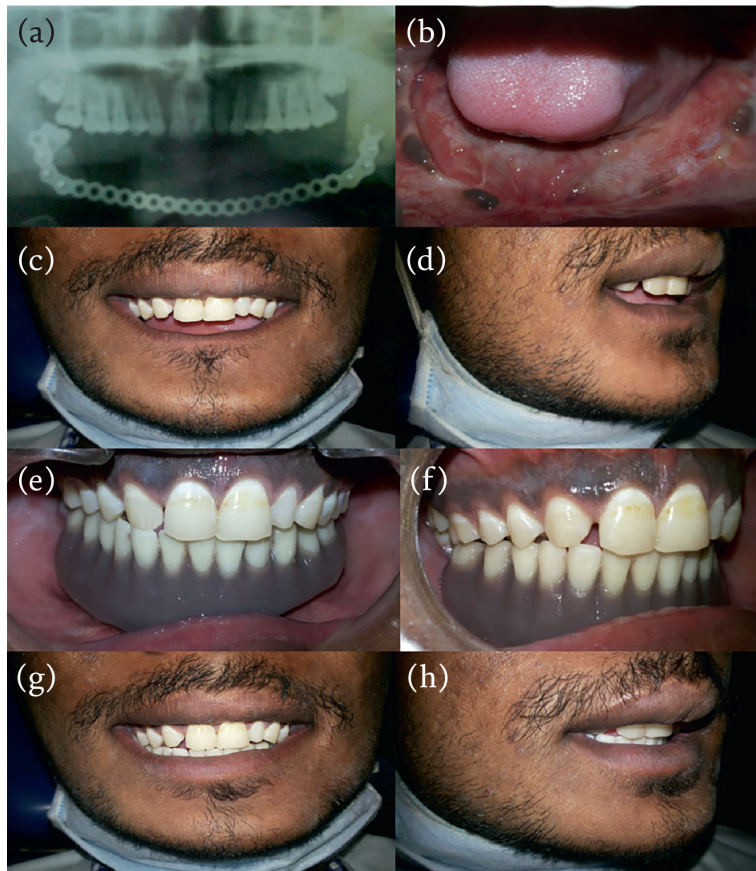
Mandibular reconstruction with alloplastic reconstructive plate. (a) Postoperative patient's orthopantomography showing segmental mandibular resection reconstructed with alloplastic reconstructive plate. (b) Intra-oral view of the patient at the time of the presentation. (c) Extra-oral frontal view photograph of the patient showing compromised lower lip support. (d) extroral lateral view photograph of the patient. (e) Intra-oral frontal view of the patient showing reconstruction with tissue borne acrylic tissue-supported prosthesis. (f) Intra-oral lateral view of the reconstructive prosthesis (g) Extra-oral frontal view photograph of the patient after reconstruction showing improved lower lip support. (h) Extra-oral lateral view photograph of the patient after reconstruction showing improved lower lip support and patient's esthetic.
